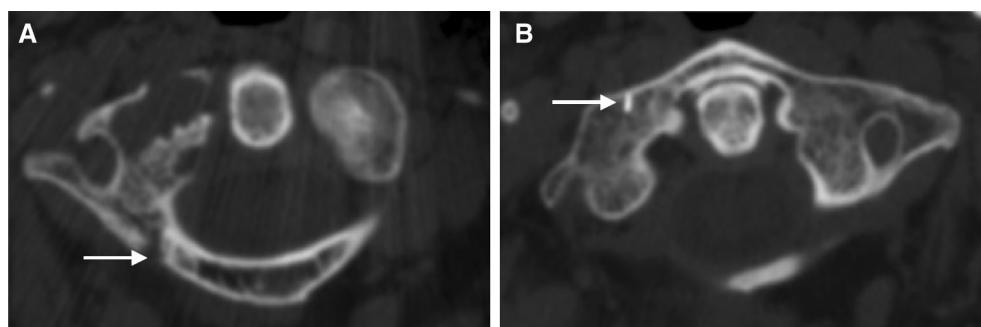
Post-operation axial cervical CT—a (arrow) entry point; b (arrow) clip concerning the biopsy point
